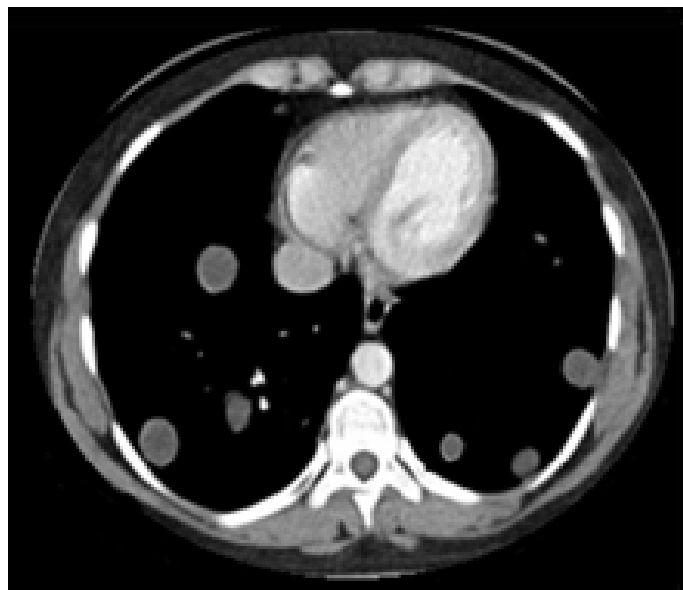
CT image shows multiple unilocular cysts in the lungs of a 26-year-old female
